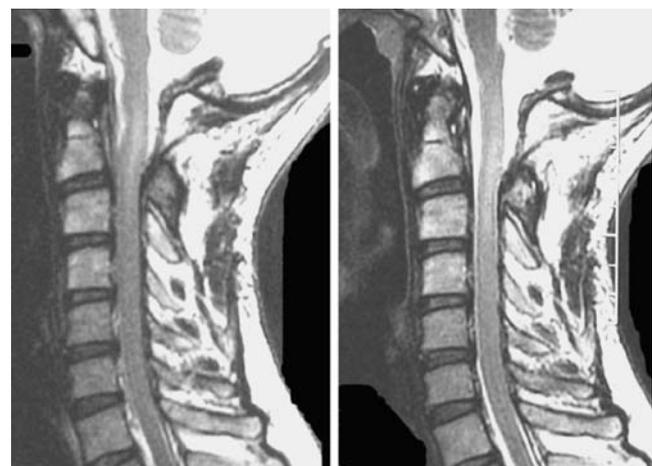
Cervical MRI of the presentation case before the CP shunt malfunction (*left*) and after the CP shunt revision (*right*). *Left* the spinal cord was tightly compressed in the narrow spinal canal, and the center of the cord revealed high signal intensity. *Right* The cord compression is released, and the subarachnoid CSF space appeared around the cord
